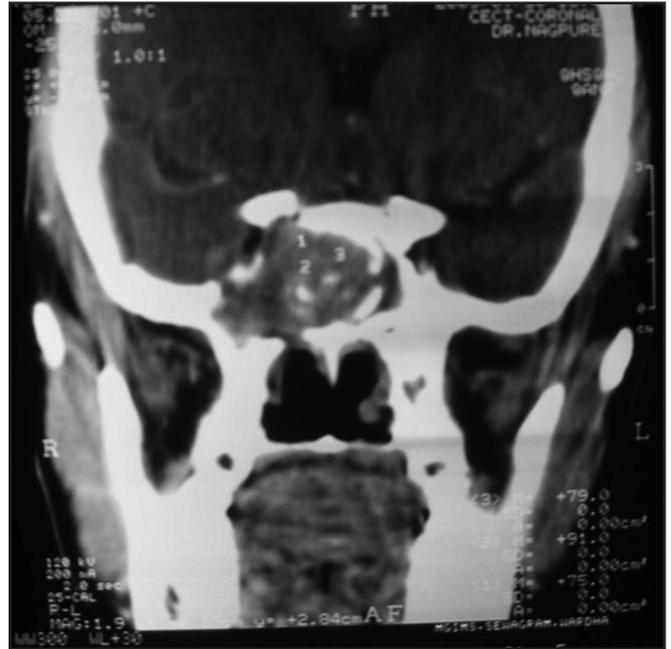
CT scan (coronal cuts) showing expansile heterogenous density mass lesion arising from sphenoid sinus with erosion of its wall.
